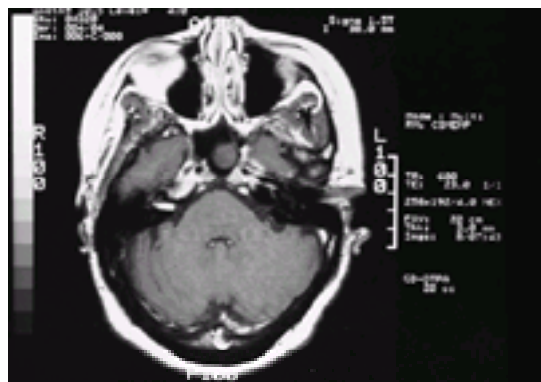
Small, right-sided, intracanalicular acoustic neuroma (*left of photograph*) on MRI scan.
